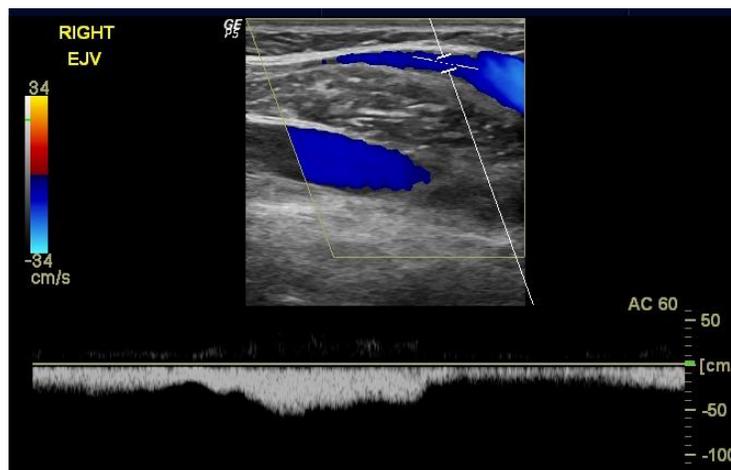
Spectral Doppler showing respiratory variations.
